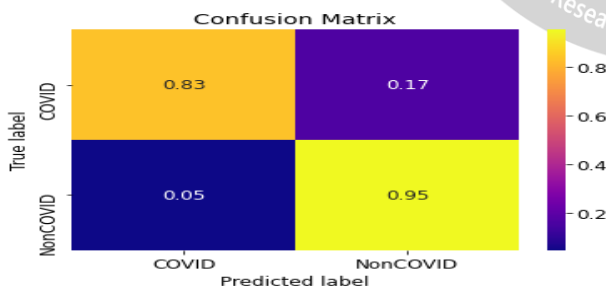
Confusion Matrix of Inception model for X-Ray images
